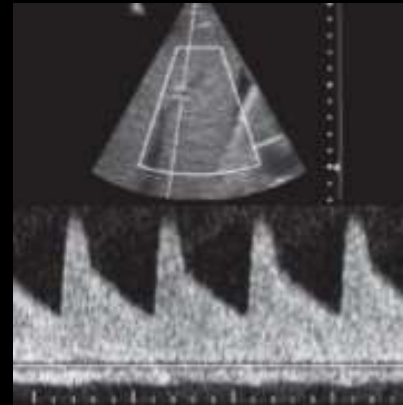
Color (a) and spectral Doppler (b) of main portal vein and hepatic artery demonstrating flow in opposite directions.
